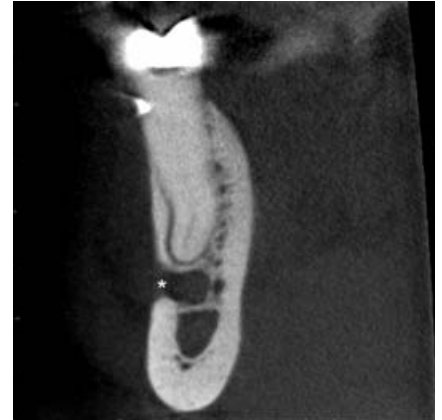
Coronal CBCT slice
